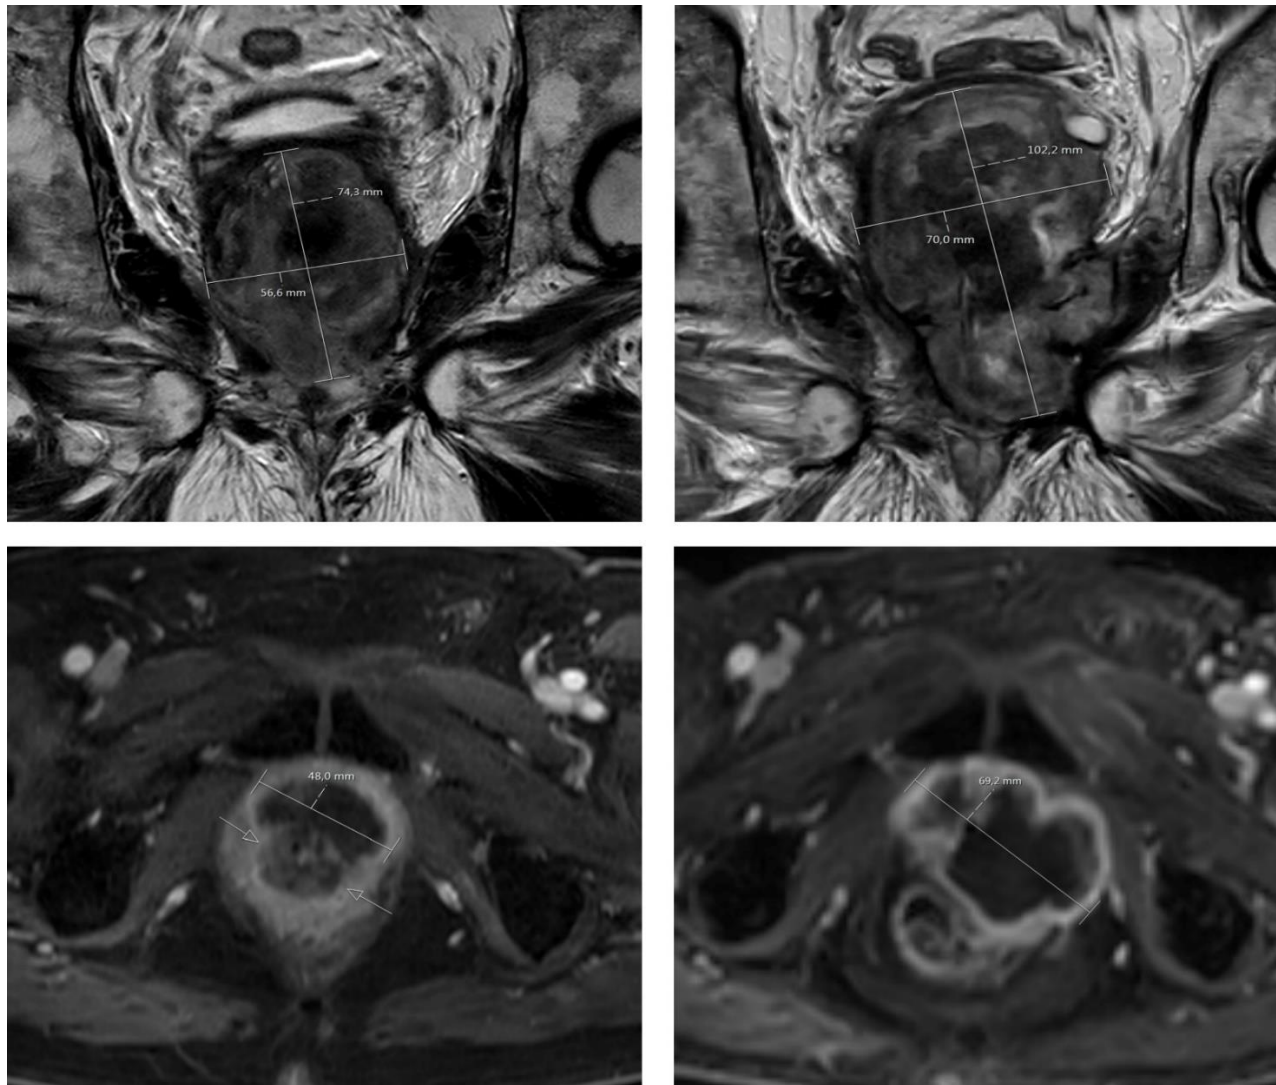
Magnetic resonance imaging findings of the prostate mass (A, B) coronal T2-weighted images showing a prostate mass before (A; 56,6 x 74,3 mm) and after two cycles of chemotherapy (B; 70 x 102,2 mm). (C, D) axial T1-weighted FS images after Gd-DTPA administration showing the prostate mass before (C; 48 mm) and after the treatment (D 62,2 mm).
